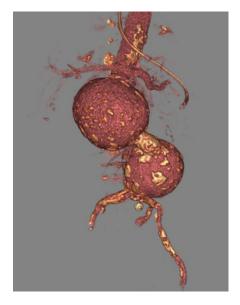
Preoperative 3-dimensional reconstruction of the computed tomography of the abdominal saccular aneurysms.
